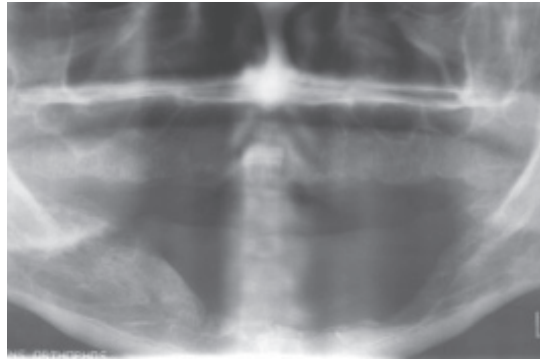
(a)–(d) Pre-operative clinical photograph, OPG, SPECT scan and MRI scan showing early tumour invasion of the mandible. (e) The resection of the buccal side of the mandible. (f) Completion of the planned coronal rim resection. (g) Turning the bone over to inspect the lingual side of the rim resection and ensure clearance of invaded mandible. (h) The resulting defect post resection. (*Continued*)
